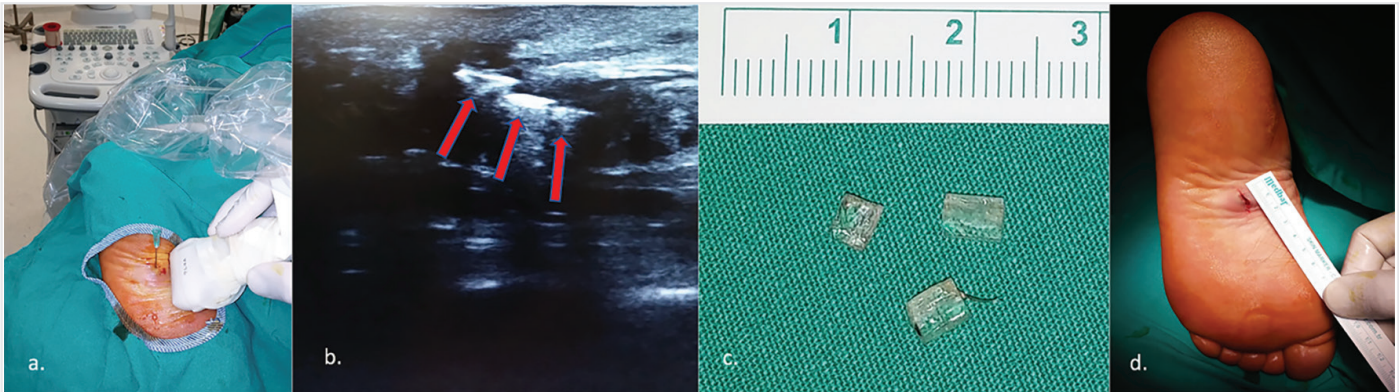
Ultrasound-assisted foreign body (glass pieces) removal from the left foot plantar area. (a, b) Localization of glass pieces under USG guidance (red arrows show the glass pieces), (c) Removed glass pieces, (d) 15 mm skin incision. (Written informed consent is taken from the patient)
